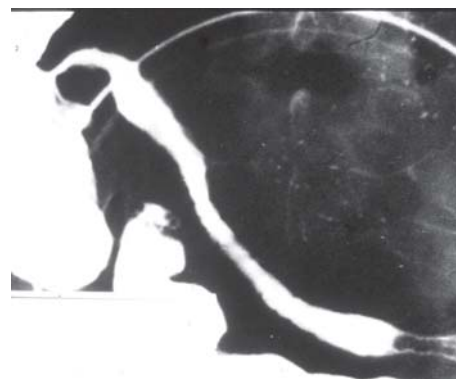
"String sign" on X-ray from narrowed gut lumen
